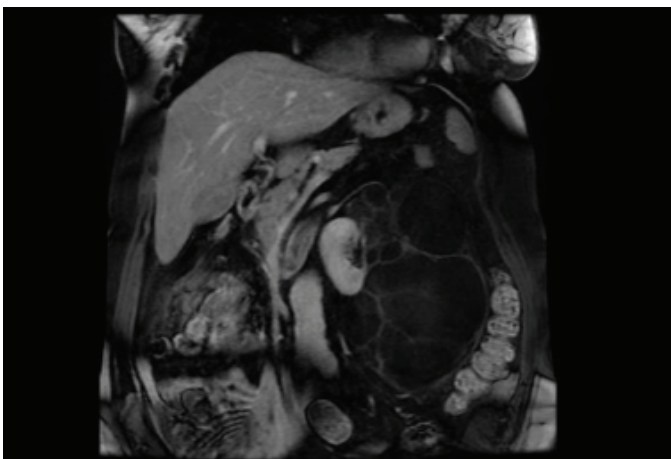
Multiple thick and some irregular septae of the multilocular septate cyst are visualized. Contrast uptake is visualized in the septae of the multilocular cystic mass consistent with Bosniak 3 on coronal contrast-enhanced T1-weighted images
